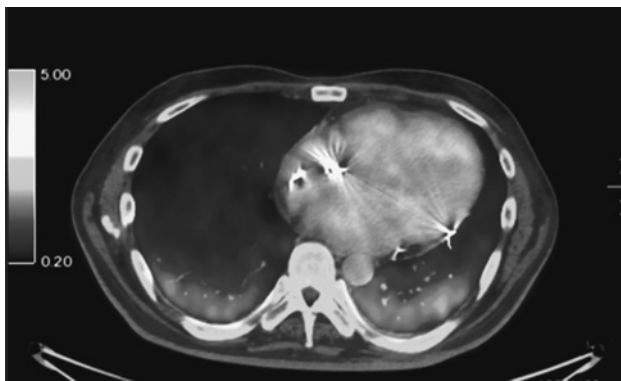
A fusion image of 18F-fluorodeoxyglucose (FDG) with positron emission tomography/computed tomography in the lower lung showing increased uptake of FDG in the dorsal area bilaterally.
